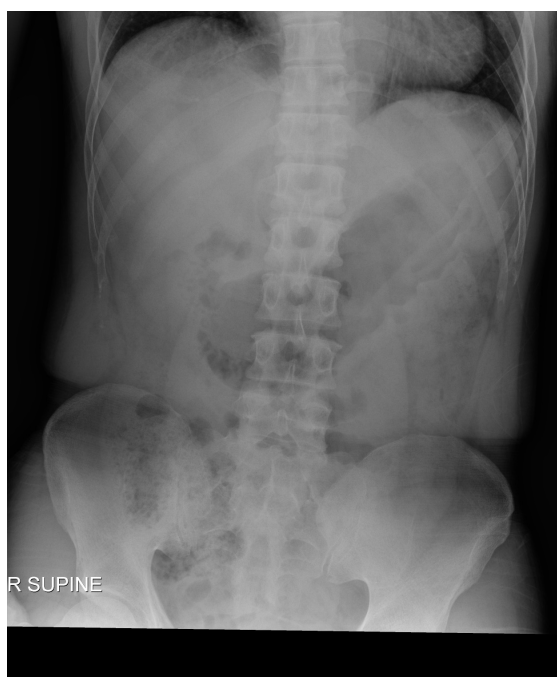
Supine abdominal radiograph without Rigler sign.*
